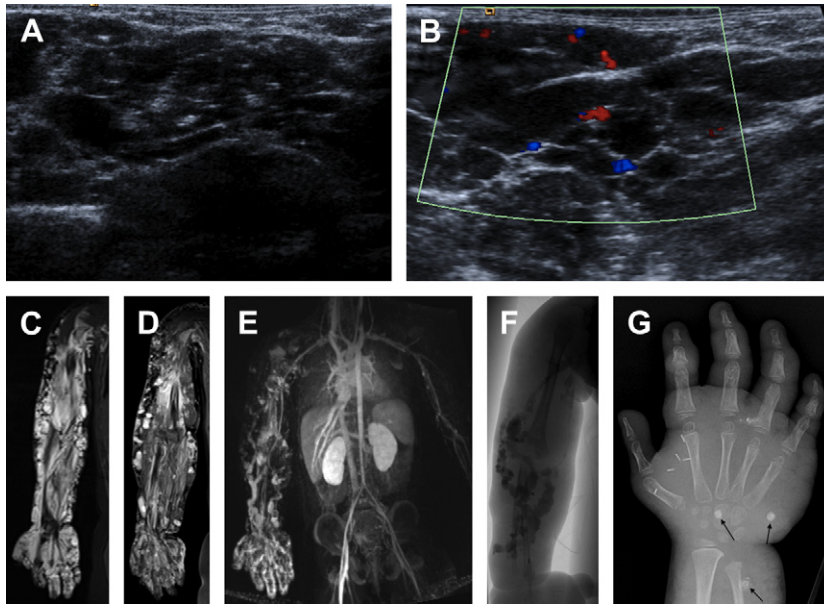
Young girl with extensive venous malformation of the right arm. US images obtained at 3 years of age demonstrate a hypoechoic, spongiform malformation (A) with little flow seen on color Doppler (B). MRI also obtained at 3 years of age. Fluid-weighted (C) and postcontrast (D) sequences demonstrate hyperintense tubular and lobulated structures involving all the soft tissue layers with heterogeneous enhancement after contrast. Post-contrast MRI (E) and conventional venography (F) clearly demonstrate the associated abnormal ectatic veins. (G) Radiograph of the right hand shows multiple phleboliths (arrows).
